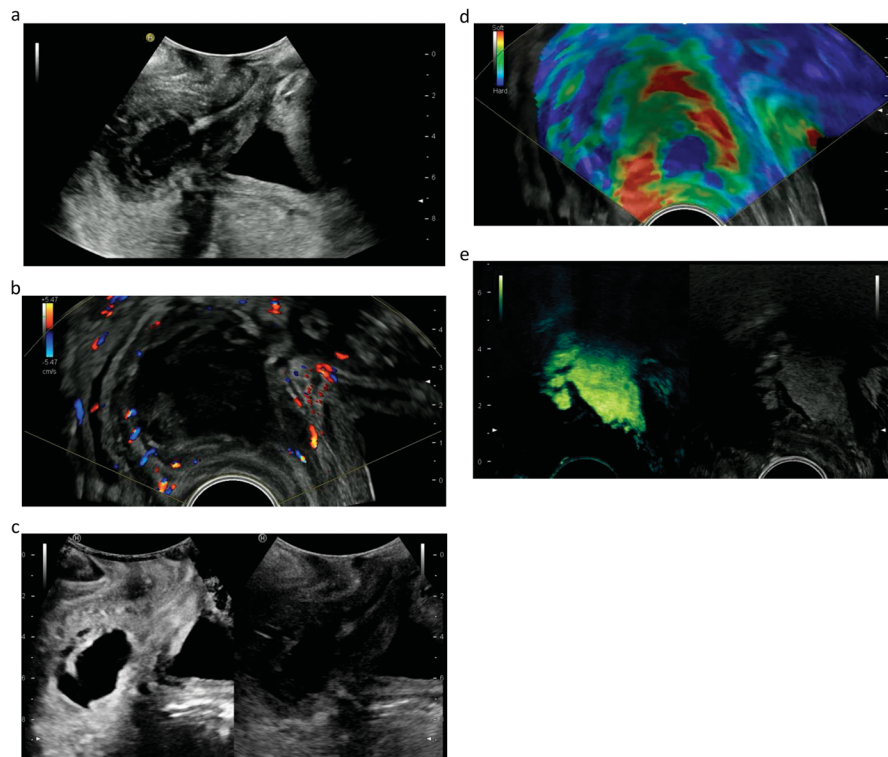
A 6-year-old boy with bicycle accident and rectal pain and fever. Endorectal ultrasound-guided puncture and drainage. B-mode ultrasound with unclear finding (A), color Doppler imaging indicating abscess or necrosis (B), contrast-enhanced ultrasound clearly delineating the abscess for needle guidance (C), strain elastography delineating the softer central parts (D), and intracavitary contrast-enhanced ultrasound excluding communication to other cavities (E).
